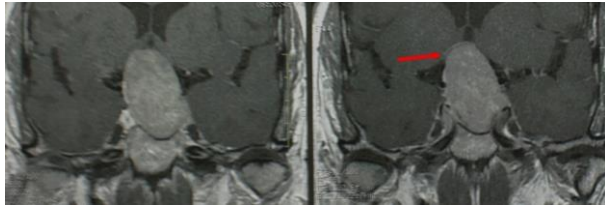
Case 3, Coronal MRI with contrast showing lesion 2.5 X 3.8 X 2.5 cm with severe chiasmatic compression and stretch.
